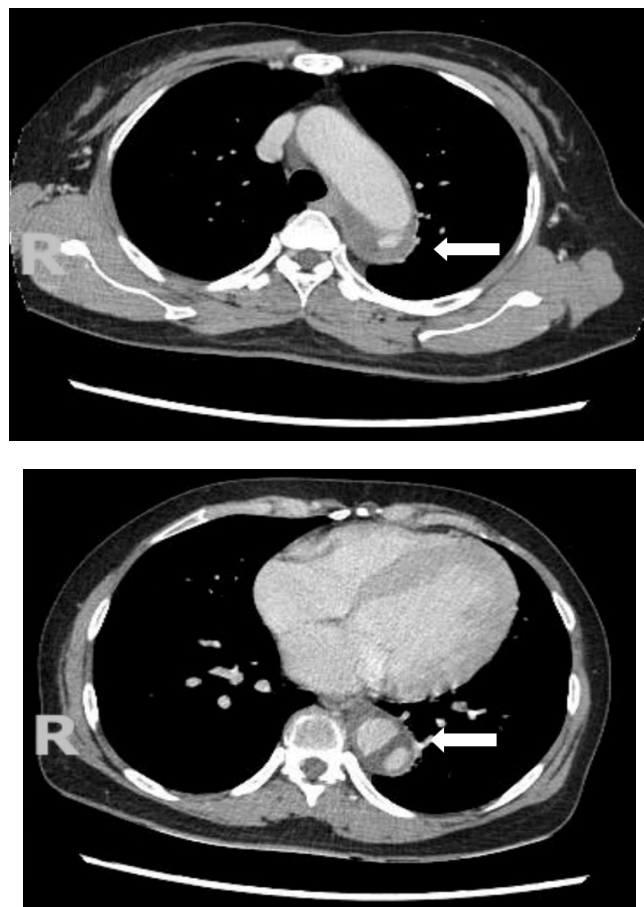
Preoperative CT scan demonstrating two penetrating aortic ulcers involving the aortic arch and descending thoracic aorta (blue arrows)
